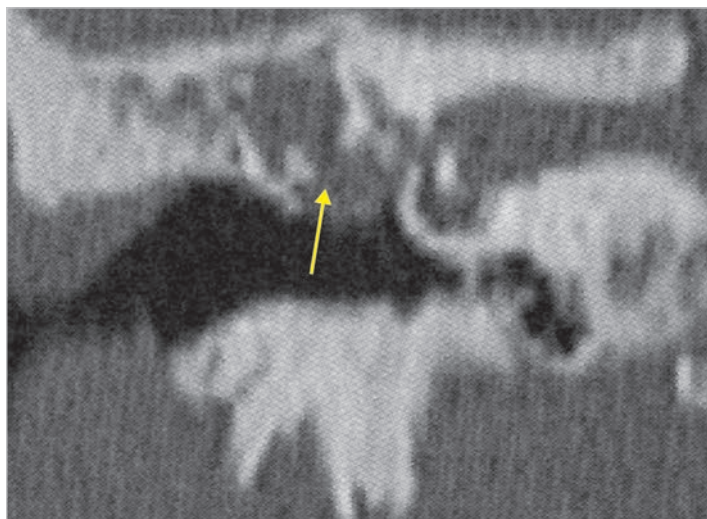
CT scan of the same case, coronal view. The cholesteatoma (*arrow*) involves the posterior epitympanum and the mesotympanic area. The hypotympanum is free of the disease.
